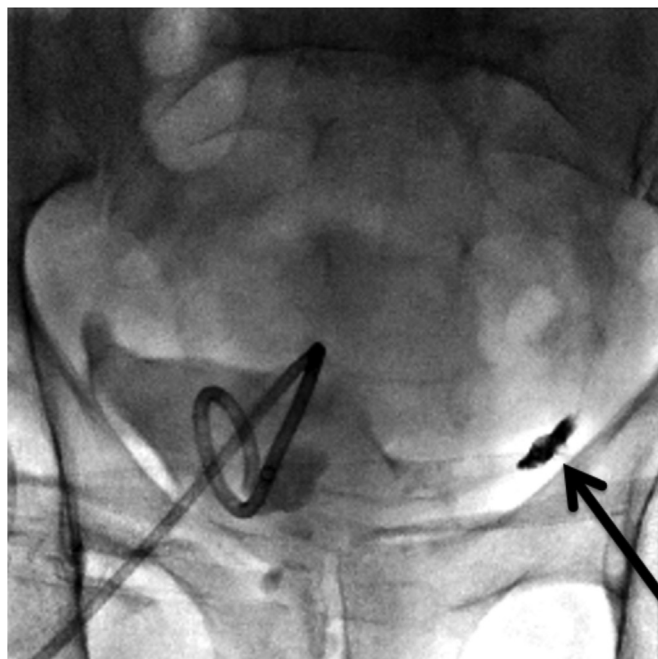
Pelvic radiograph following the deposition of nBCA glue/Lipiodol in the left iliac lymphatic leaking channel (arrow) through the lymphocele.
